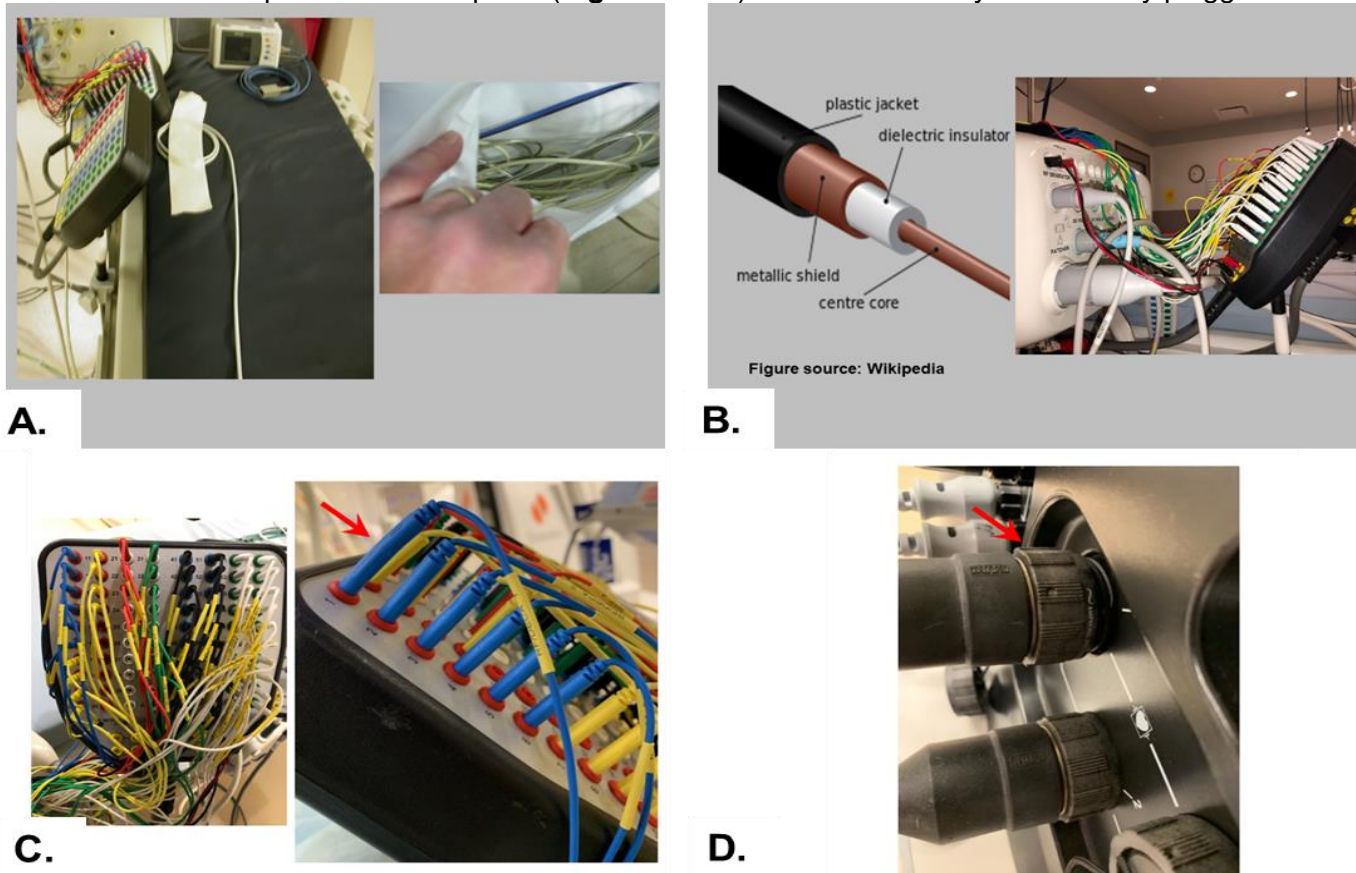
Equipment placement. A. CARTO power supply converts AC to DC; PIU is run by DC power sources. This power supply is placed at a distance from the CARTO-3 PIU which is mounted on the rail of the x-ray table. B. Unused cables are placed on top of the CARTO-3 PIU to avoid picking up electromagnetic interferences because this plastic box is powered by DC current.
